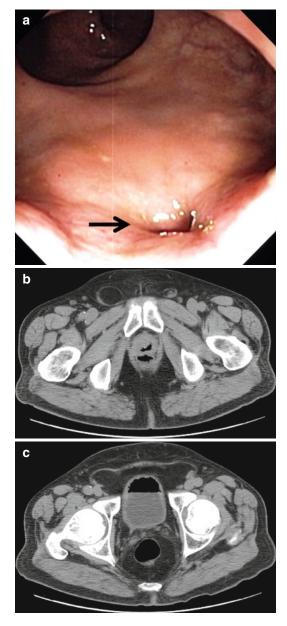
Prostatorectal fistula after cryotherapy for low stage prostate cancer. (a) Colonoscope view of fistula (*arrow marks* fistula). (b) Pelvic CT of the fistula. Note air in prostate and rectum (noninstrumented system). (c) CT demonstrating air in bladder (noninstrumented system)
